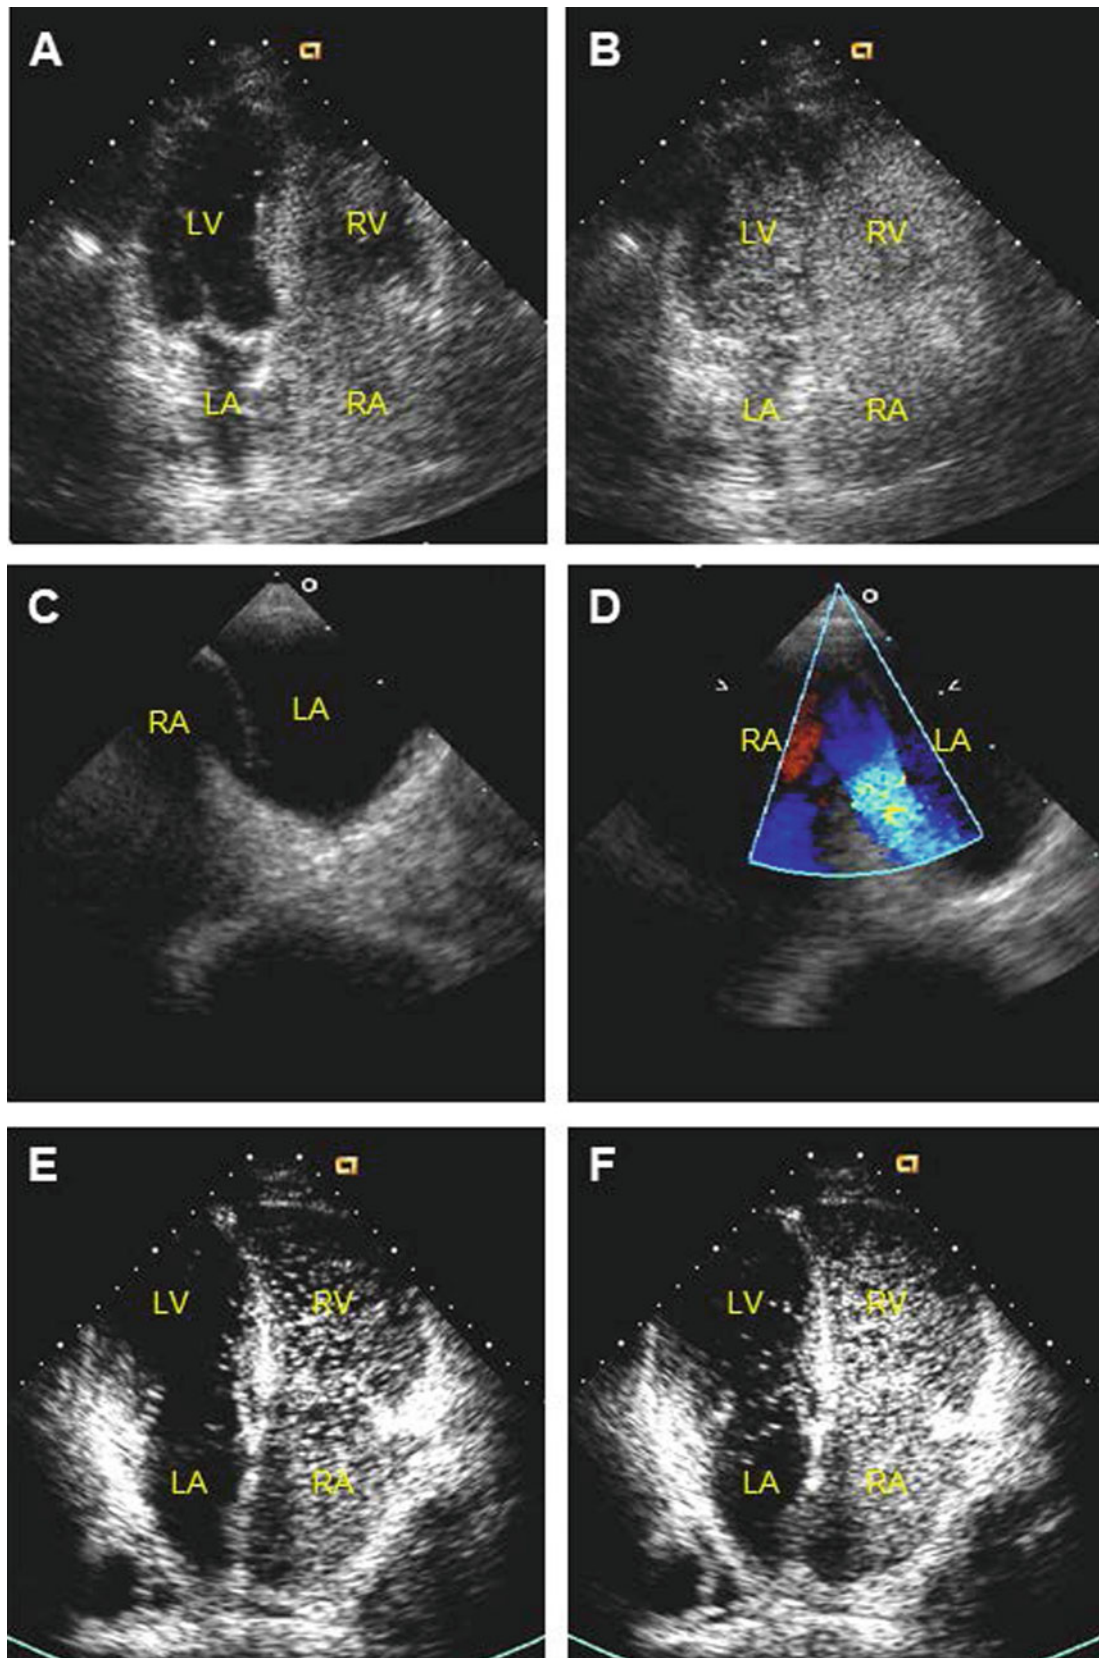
PFO with right-to-left shunt. Baseline transthoracic echocardiogram with agitated saline shows entry of bubbles into the RA and RV (A) followed immediately by near opacification of the left atrium and ventricle (B) suggesting the presence of a large right-to-left shunt. Transesophageal echocardiography confirms the presence of a PFO
